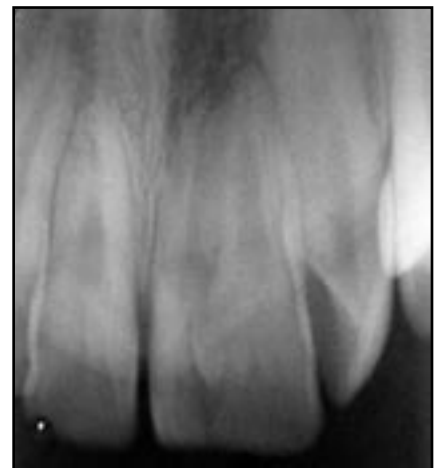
Pretreatment periapical film of the central incisor fused to a supernumerary tooth.
